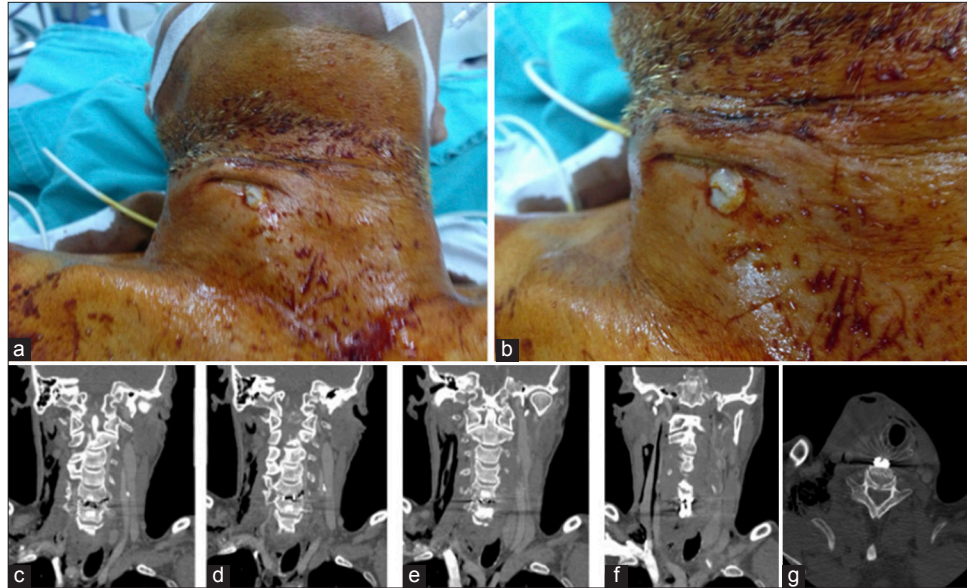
Inspection of the patient shows (a, b) drainage of the collection from the incision site. (c-g) Cervical spinal computed tomography sections of the patient show air images and collection in the surgical site.
